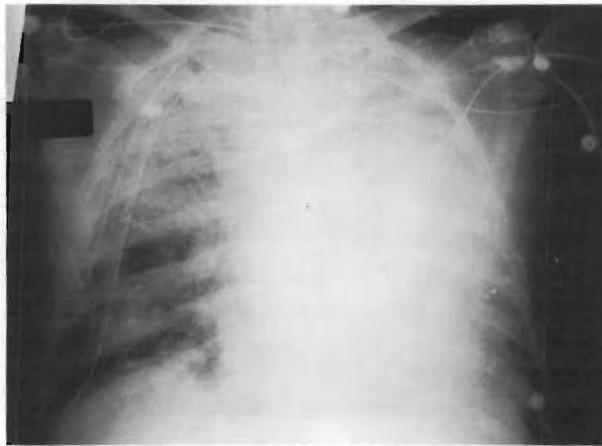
Chest x-ray demonstrating severe white-out of the lungs representing PCP, CMV pneumonitis and PTLD of the lung with respiratory failure.
